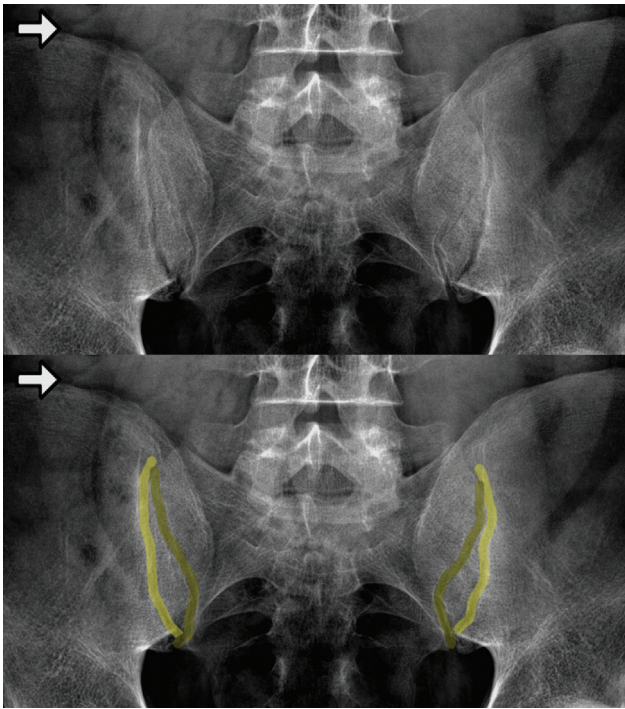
A 38-year-old man. Anteroposterior radiograph of the sacroiliac joints (SIJs) shows normal SIJs with uniform width and smooth outlines bilaterally. The anterior part of the joint space is marked in light yellow, the posterior part in dark yellow (reproduced with permission from Medisfera, Radiographic Atlas of Inflammatory Rheumatic Diseases. Otwock, Poland).⁴¹
